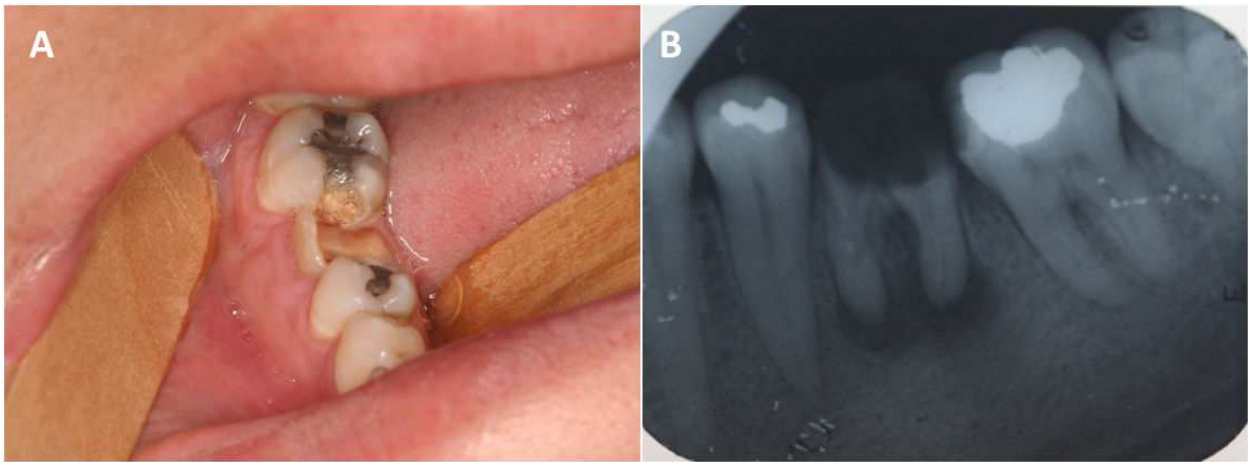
Clinical (A) and radiographic(B) aspects of a periapical lesion.
